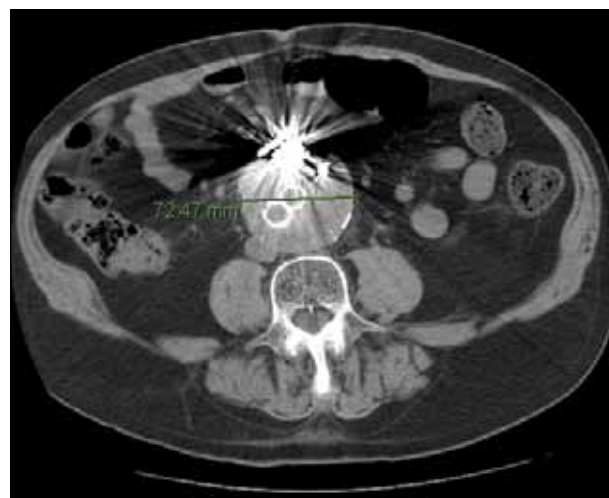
Surveillance CTA after embolization showing aneurysm shrinkage.
